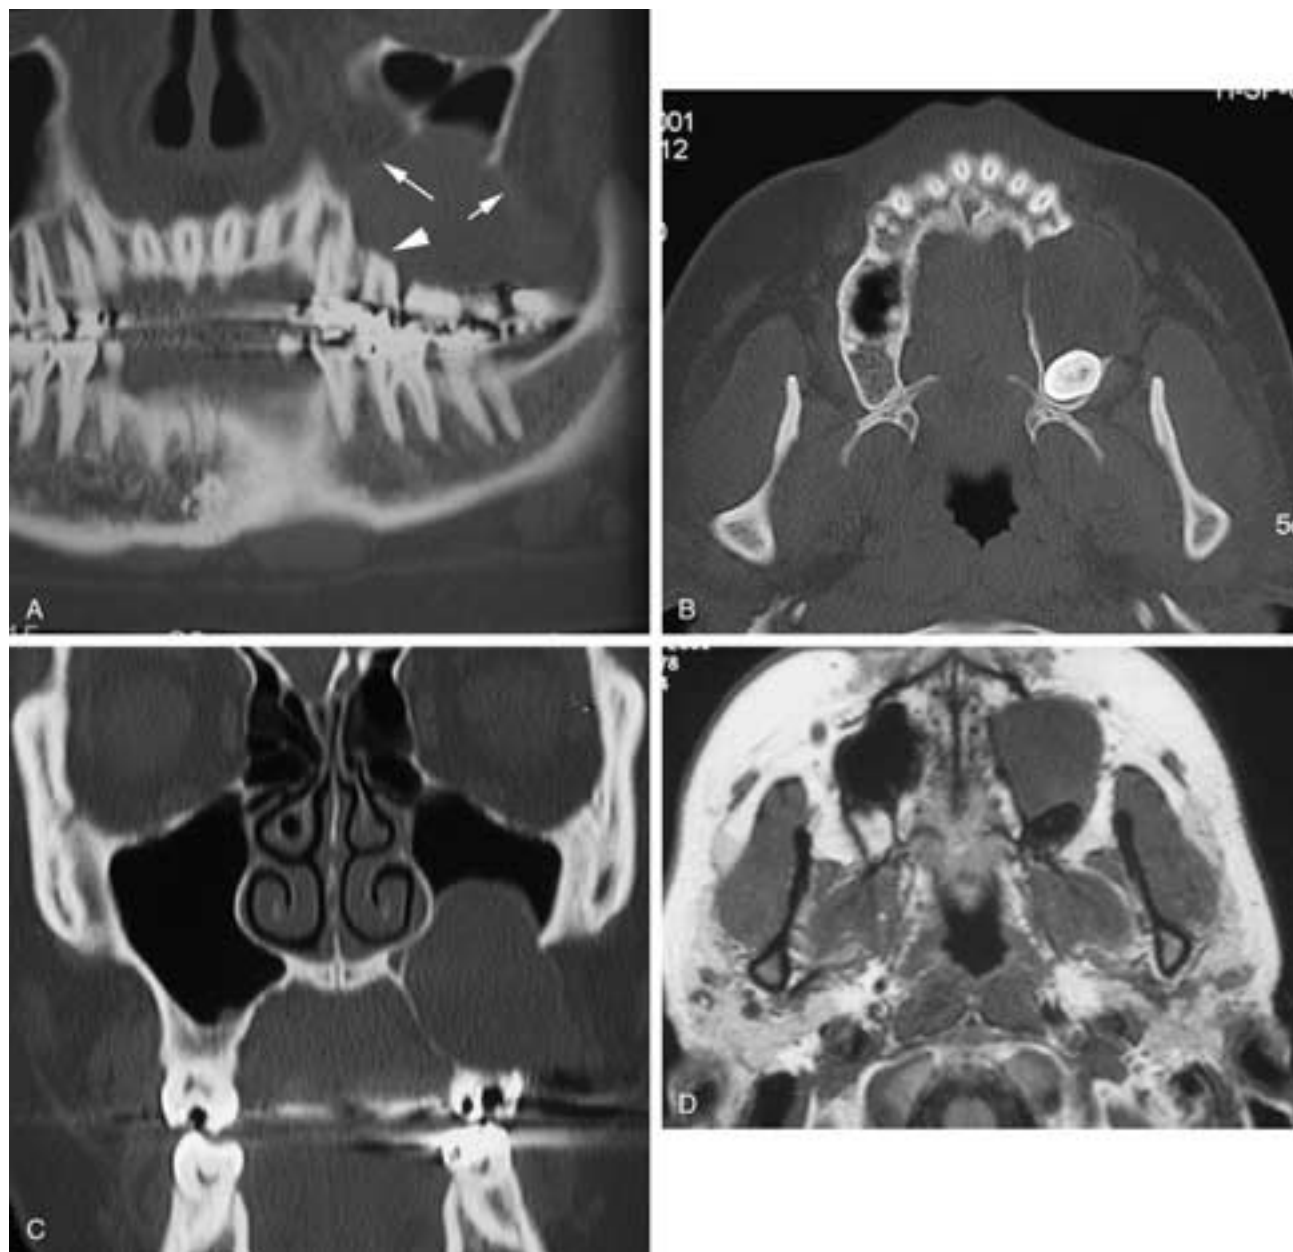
OKC. A, Panoramic reformat from multidetector spiral CT scan. The OKC is seen as an expansile abnormality in the left maxilla. Note the intact cortical line (*arrows*) as the lesion expands outward. Multiple root tips (*arrowhead*) are shortened and eroded. B, Axial bone algorithm CT shows the expansile abnormality in the lower maxilla. The lesion does have a relationship to the unerupted molar but does not show the typical configuration of a dentigerous cyst. C, Coronal CT shows the expanding abnormality enlarging the alveolar process and extending into the maxillary sinus. D, Axial T1-weighted MR image. The lesion shows low signal intensity.
